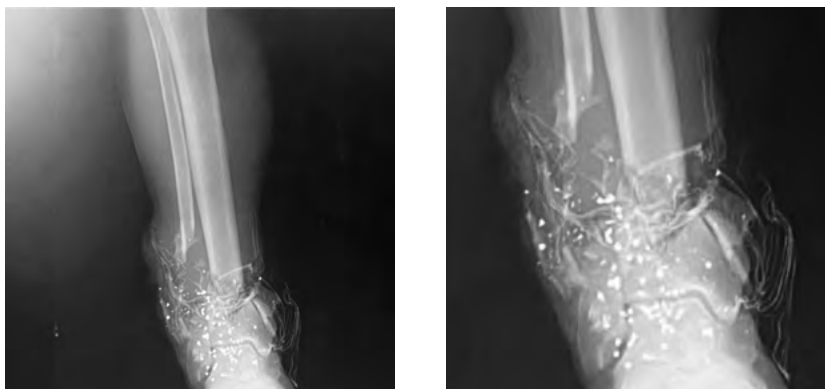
Preoperative plain radiographs. Anteroposterior (AP) view of the right lower leg/ankle
